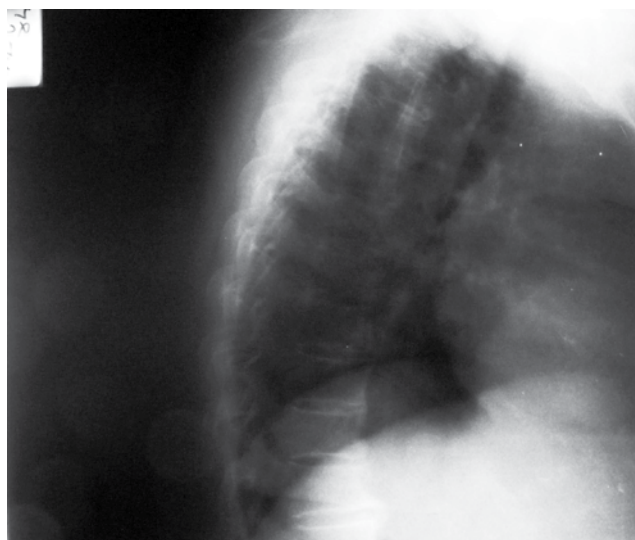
B) Lateral radiograph of the thoracic spine
